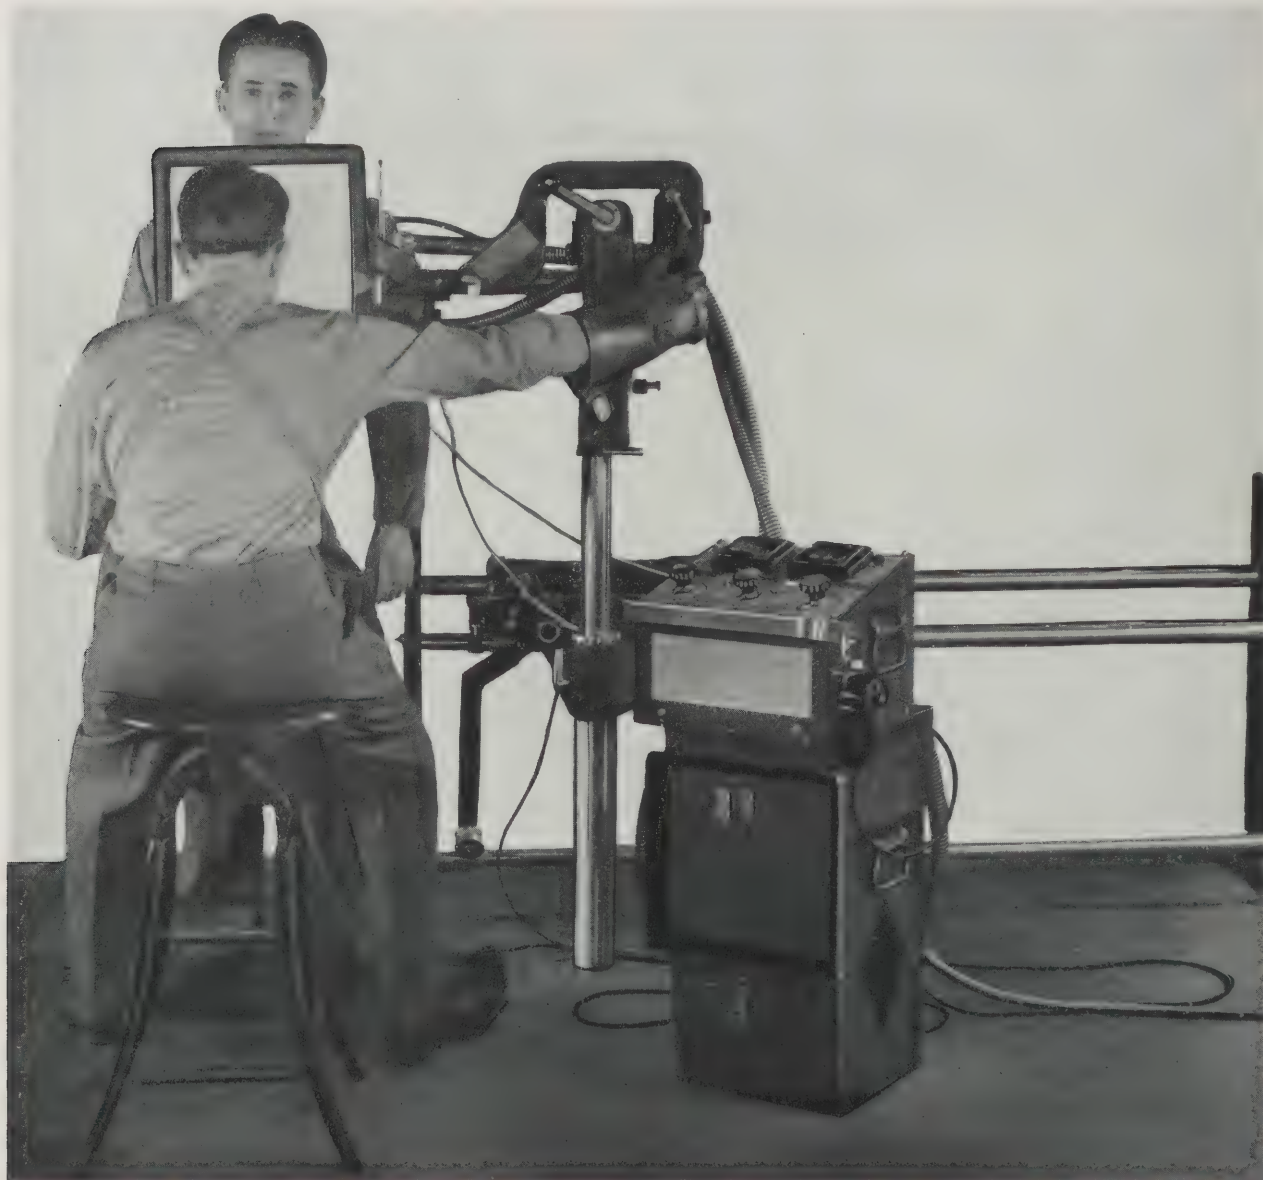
Item 96085 assembled with Item 96145 and in position for standing roentgenoscopy.
